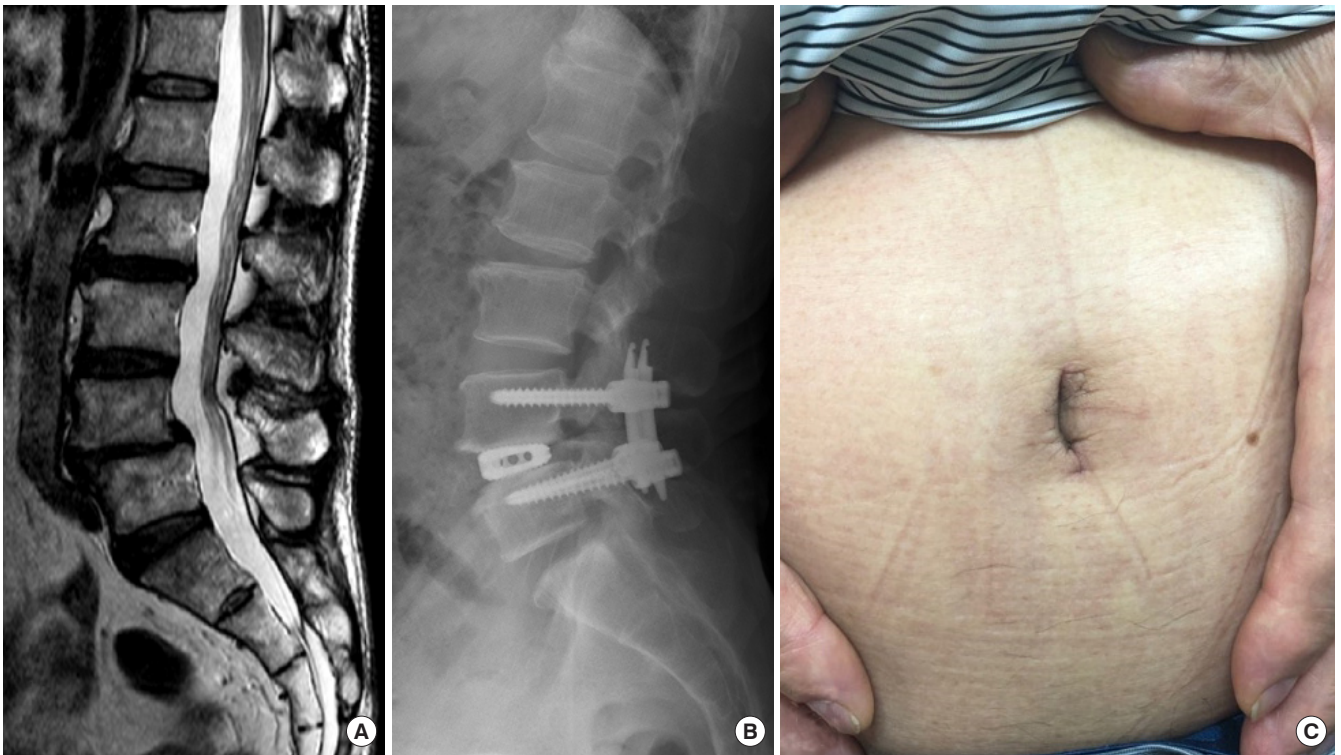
(Case 1) Preoperative magnetic resonance imaging scan (A), postoperative x-ray (B), and photograph of the abdominal scar after 6 months postoperatively (C).
